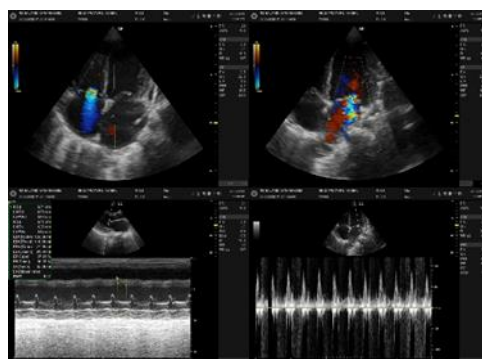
Echocardiography result.
